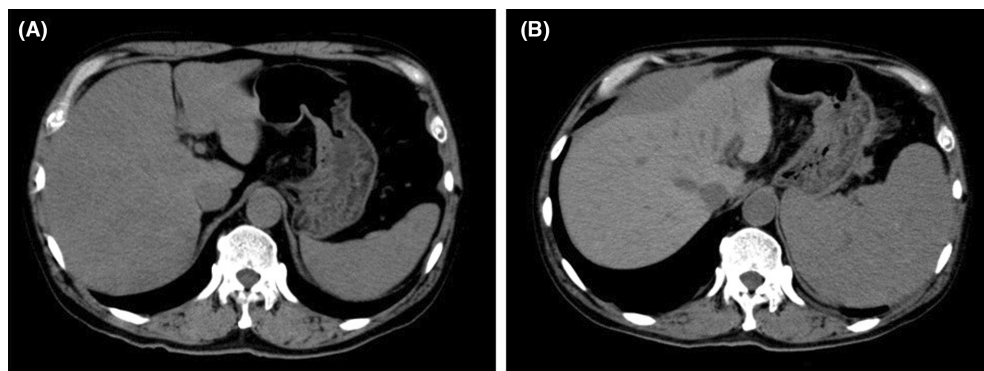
Horizontal sections of computed tomography (CT) of the upper abdomen. (A) A horizontal section of the upper abdomen performed at the presentation of paralysis of the lower extremity. (B) A CT performed 2 months after the first CT presenting with a syncope episode demonstrates a remarkably enlarged and ruptured spleen with intraperitoneal hemorrhage.
